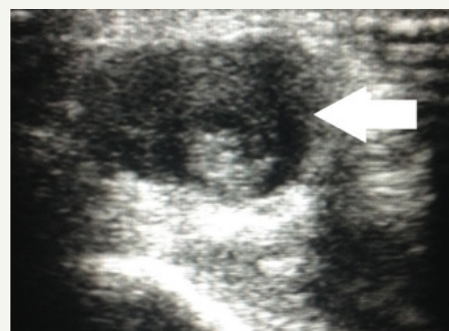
Ultrasonography without Doppler demonstrating thrombosis in the distal radial artery (white arrow).
